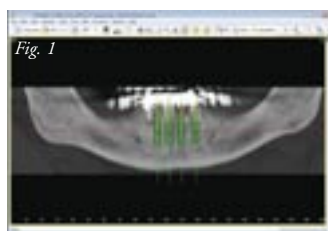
The CT scan verifies the bone density and thickness.
